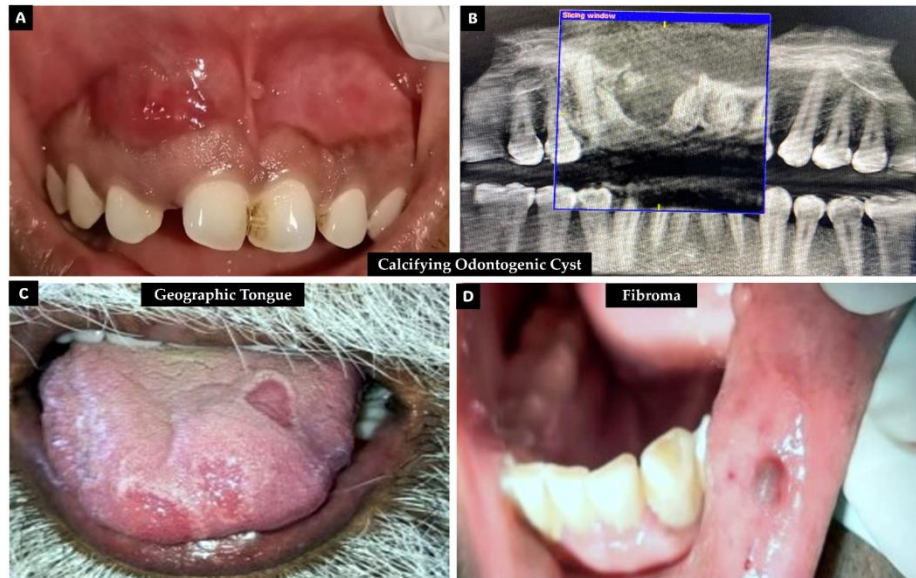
(A) Intra oral image showing the clinical picture of labial mucosa of maxillary anterior region involved due to calcifying odontogenic cyst (B) Cone beam computed tomographic image showing a central radioopaque mass within a radiolucent cyst with a clear radiopaque lining (C) benign migratory glossitis or geographic tongue showing parts of tongue denuded or devoid of papillae (D) traumatic fibroma of the lower lip showing a small fibrotic swelling
